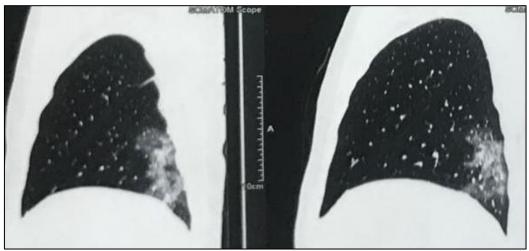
HRCT thorax showing pleural based consolidation with line of demarcation in right lower lobe
